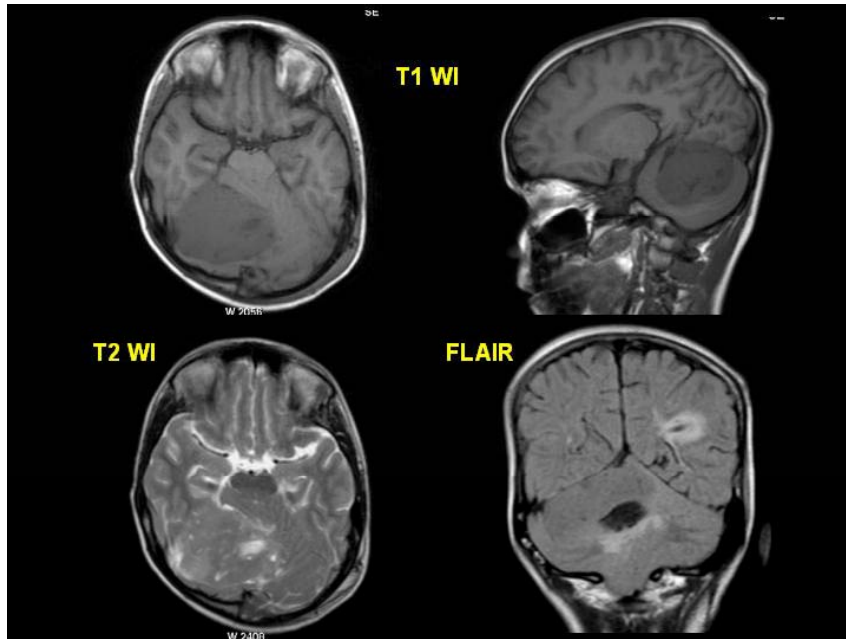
MRI shows a large, well-defined extra-axial neoplasm arising from the tentorium on right side causing mass effect on the cerebellum with tonsillar herniation -meningioma
